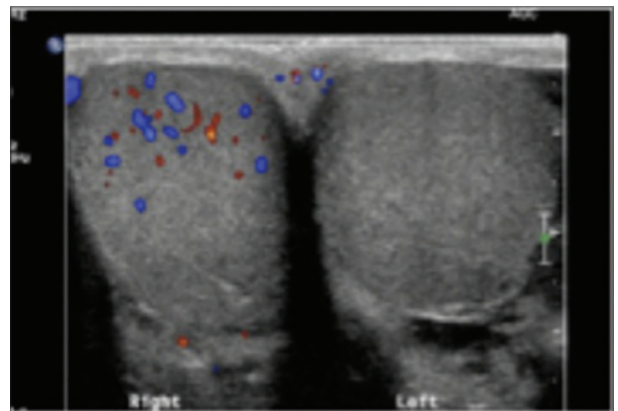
Color Doppler ultrasonogram demonstrating normal flow to the right testicle and absent flow to the left.
